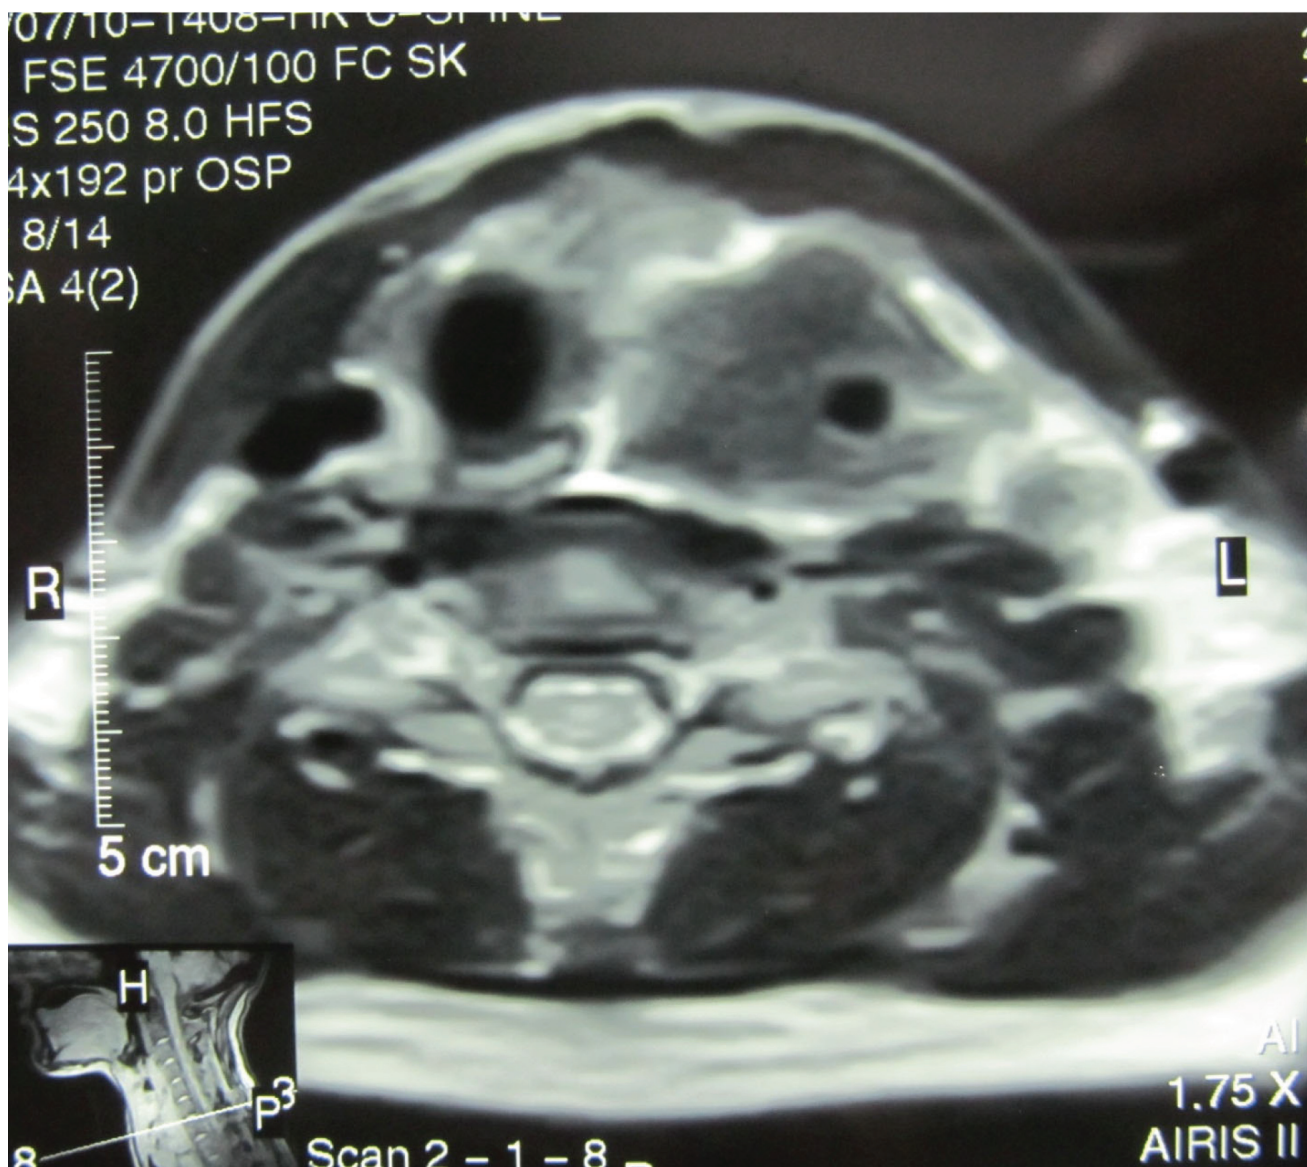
Magnetic resonance imaging of thyroid shows left side inhomogeneous thyroid enlargement encasing left common carotid artery.
